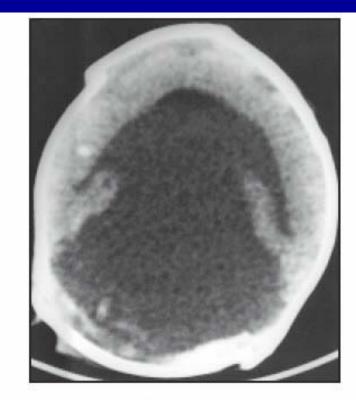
CT scan brain showing absence of midline structures, a single ventricle with thinned out cortex
